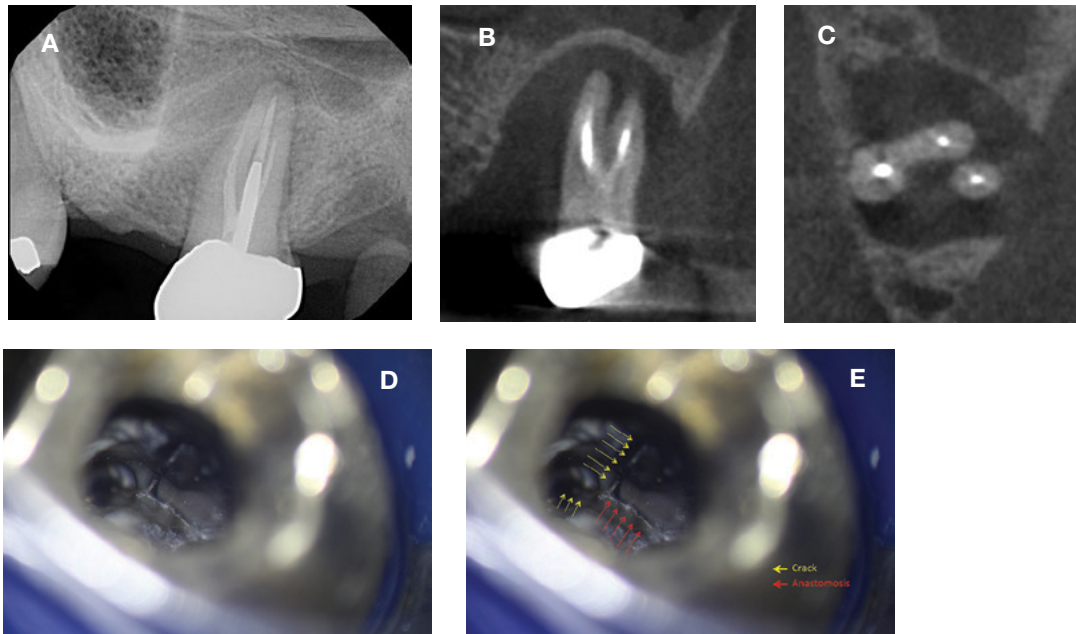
This asymptomatic molar (A) had extensive bone loss revealed by the CBCT (B, C). Despite the poor prognosis, the patient wanted nonsurgical root canal therapy to attempt to save her tooth. After removing the root filling materials (D), a large vertical fracture (yellow arrows) was found on the mesial wall of the access preparation extending down into the mesio-buccal canal and contacting the mesio-palatal root pulpal anastomosis (red arrows). The prognosis is unfavorable.
